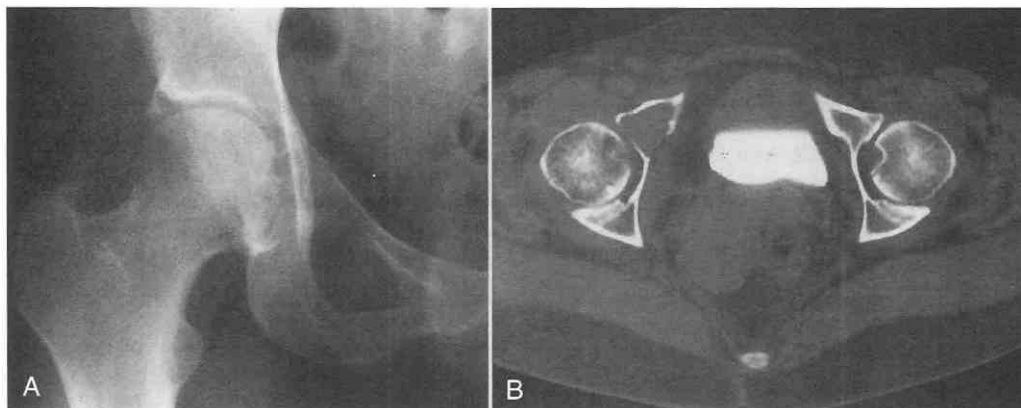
Multiple myeloma. *A*, Radiograph of the right hip demonstrates a lytic lesion of the superior pubic ramus. *B*, CT scan confirms the presence of a lytic lesion with destruction of the cortex posteriorly. No sclerotic borders are seen.
